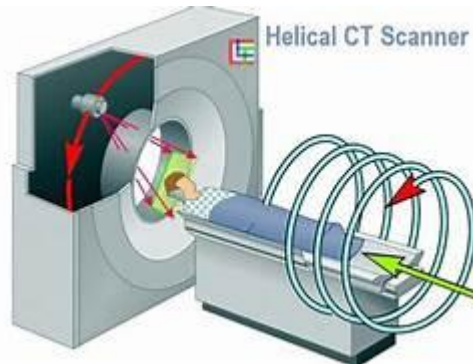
spiral or helical CT scanner
